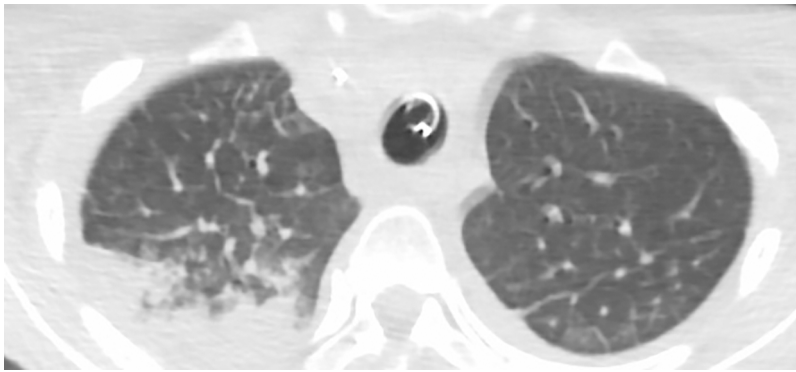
CT Chest showing bilateral confluent infiltrates with consolidations and small bilateral pleural effusions.
